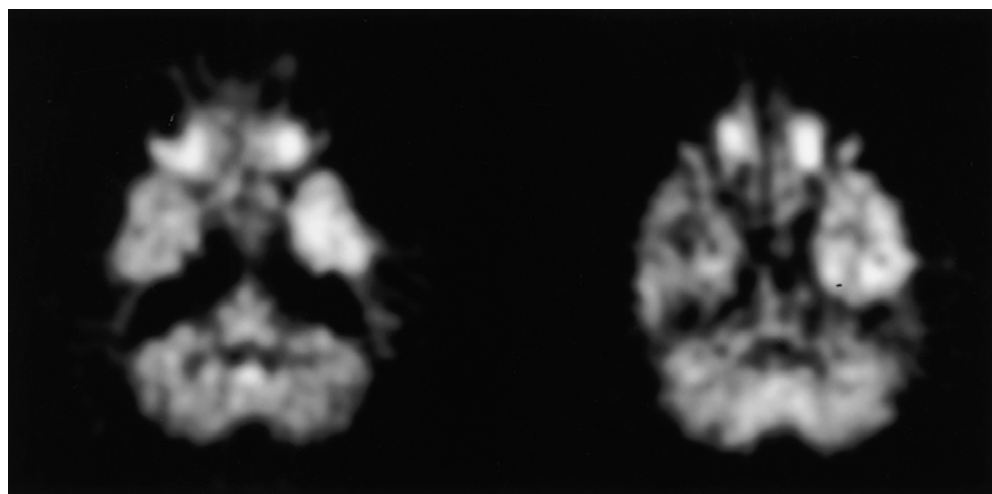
Transverse brain FDG-PET scan of a 14-year-old girl shows a hypometabolic epileptogenic right temporal lobe. (Reprinted with permission from Jadvar H, Connolly LP, Shulkin BL, Treves ST, Fischman AJ. Positron-emission tomography in pediatrics. Nuclear Medicine Annual 2000;53–83.)
